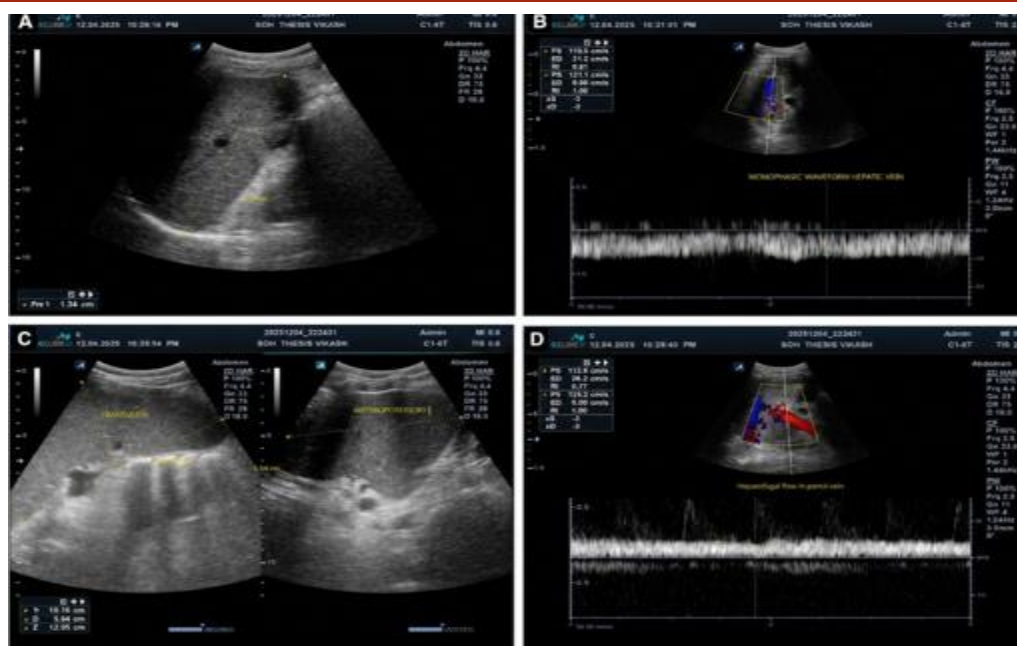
B-mode and Doppler ultrasonographic findings in a patient with Child–Pugh class C liver cirrhosis. (A) Liver showing a regular surface and heterogeneous echotexture. (B) Monophasic hepatic venous waveform. (C) Splenomegaly. (D) Hepatofugal flow in the portal vein
